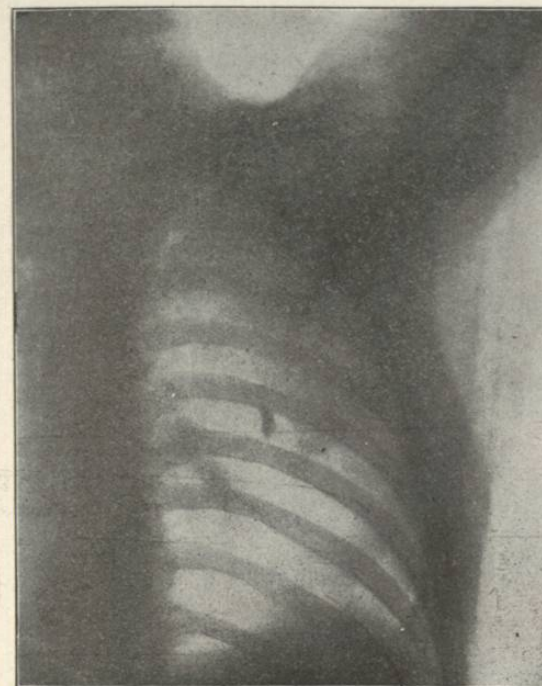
Radiograph Showing Mauser Bullet, Deformed by Ricochet, lodged in Right Back opposite Seventh Intercostal Space.
